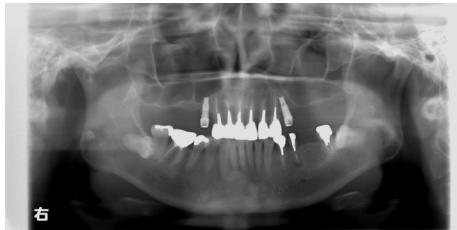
Panorama radiograph at the postoperative visit
